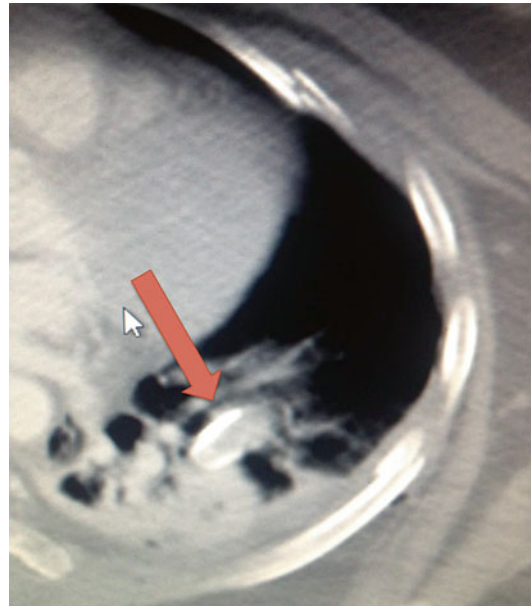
This CT scan demonstrates impalement of the lung by a displaced posterior rib fracture (*red arrow*). This degree of visceral injury by a rib fracture represents, in itself, an indication for surgical extrication, fracture reduction, and fixation, irrespective of the overall injury pattern of the chest wall
